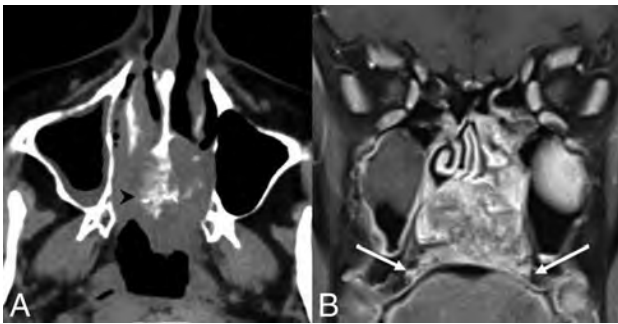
HPV-related multiphenotypic sinonasal carcinoma. Axial non-contrast CT (A) and coronal T1 postcontrast, fat-saturated (B) MR images show an aggressive mass centered in the inferior nasal cavity. The mass is isodense to muscle with an aggressive periosteal reaction along the nasal septum (*black arrowhead*). The mass is enhancing and locally destructive, invading the marrow of the hard palate (*white arrows*).
